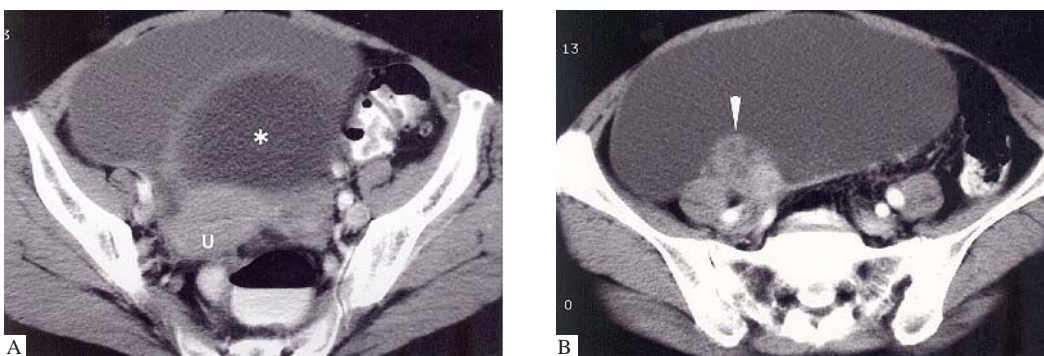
Axial computed tomography (CT) scan of the same patient showing (A) a large thin-walled cystic mass in the right iliac fossa, superior and to the right of the uterus and urinary bladder, with (B) an approximately 4-cm solid nodular component at its right posterior wall (arrowhead). [*: Bladder; U: Uterus]
